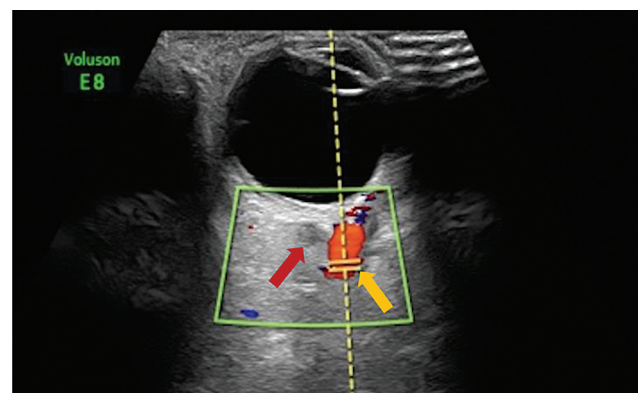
Image showing spectral and color mode Doppler representing the ophthalmic artery (yellow arrow) medial to the optic nerve (red arrow).
